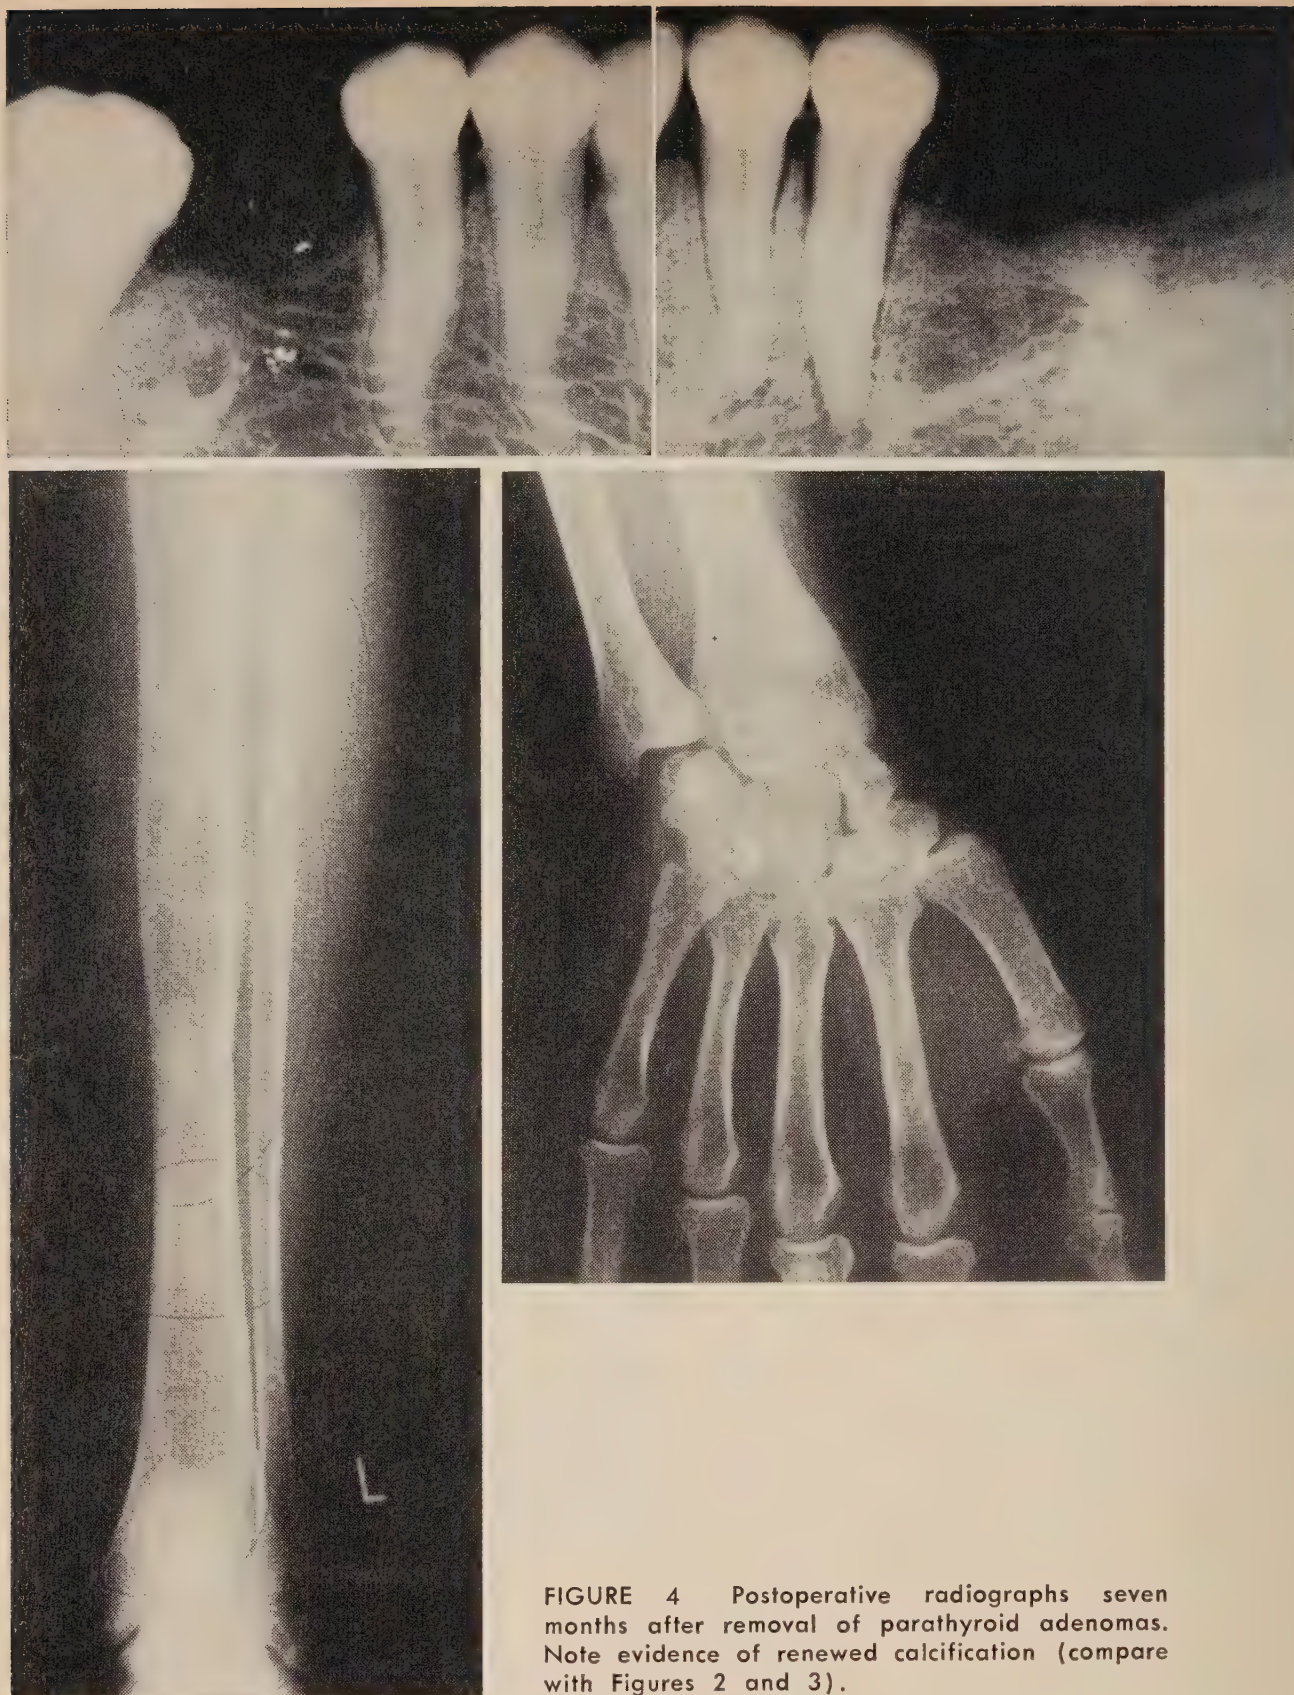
Postoperative radiographs seven months after removal of parathyroid adenomas. Note evidence of renewed calcification (compare with Figures 2 and 3).
